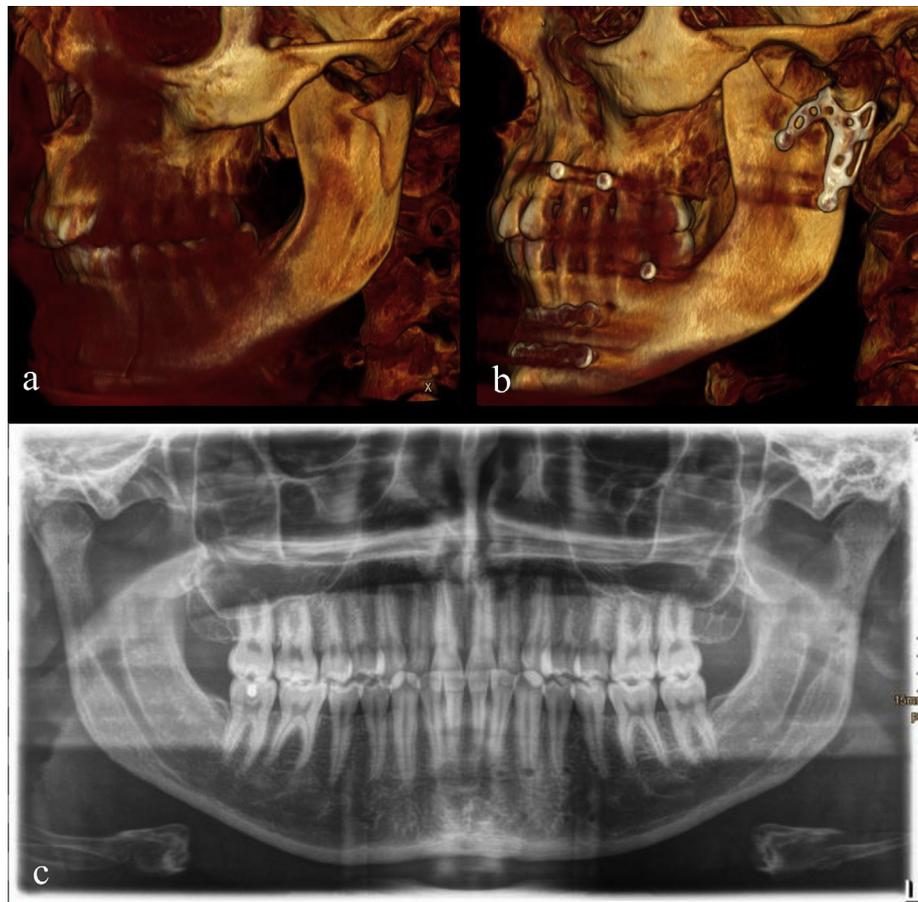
Pre- and postoperative tree-dimensional imaging as well as panoramic radiograph showing conditions after removal of plates 6 months post-surgery in patient No. 3.
